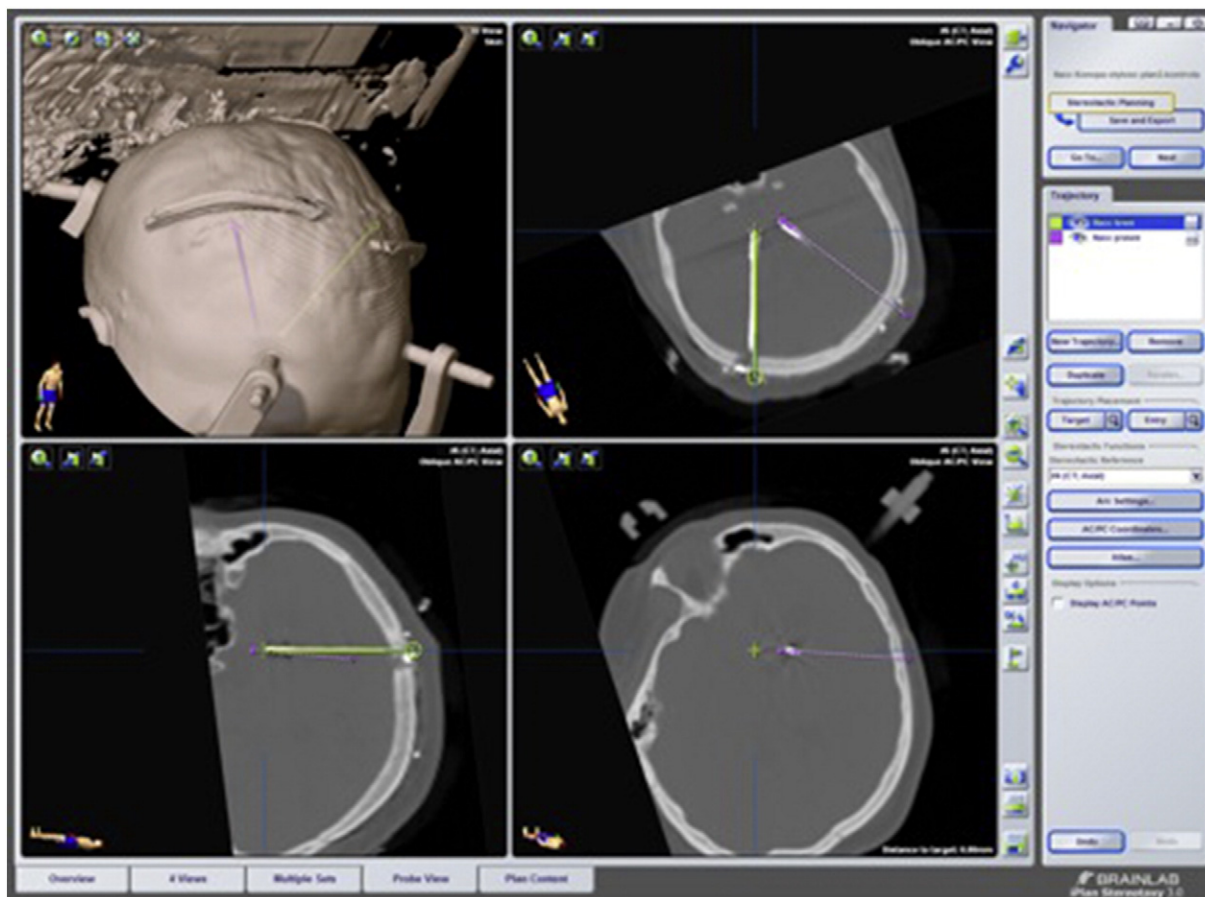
Postoperative CT showing tips of electrodes fused to bilateral trajectories of planned STN DBS.
